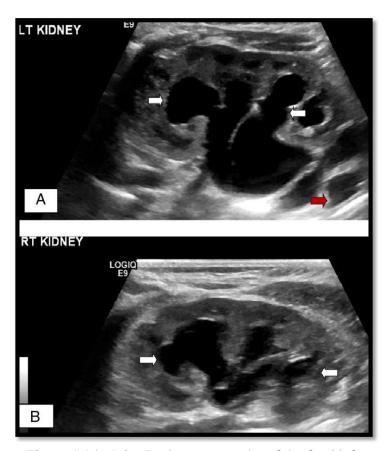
A 2 – D ultrasonography of the fetal left and right kidney (a & b) showing bilateral hydronephrosis (white arrows) and hydroureters (red arrows) (Rabah & Al-Nabhani, 2018)
